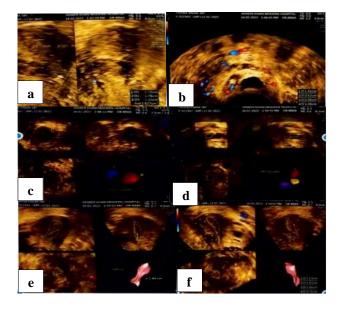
(a-f) Ultrasound of the patient.
